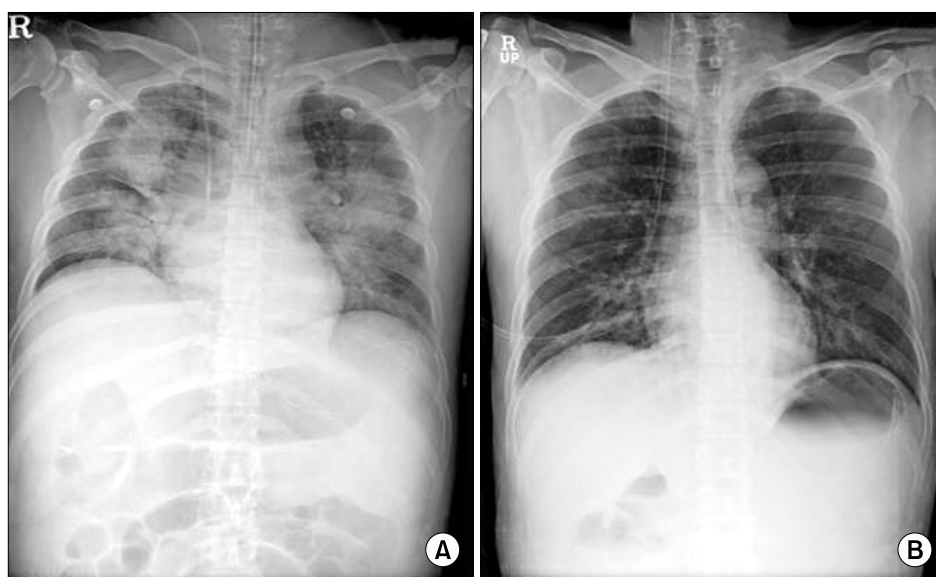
Chest X-ray of the patient showing multifocal patchy consolidation consistent with aspiration pneumonia (A) and the decreased extent of pulmonary opacification in both central lung areas 3 days after initiation of the treatment (B).
